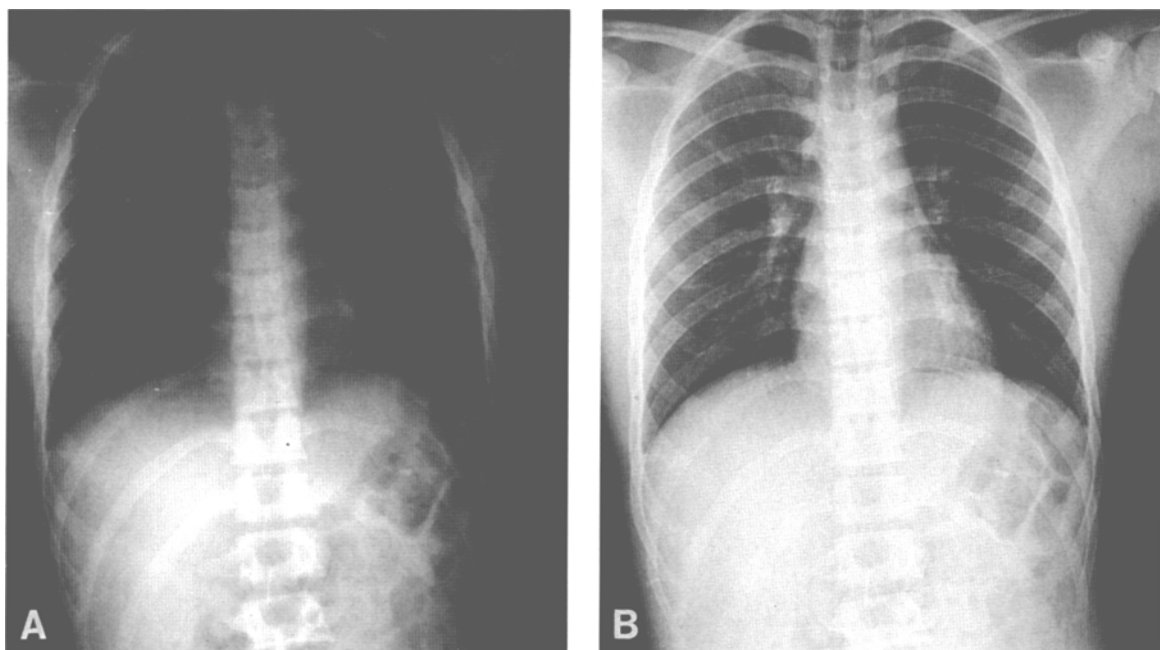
(A) Original portable chest radiograph with an overexposure level of 400% of the proper level. (B) Digitized processed chest radiograph that provides markedly improved diagnostic quality.
